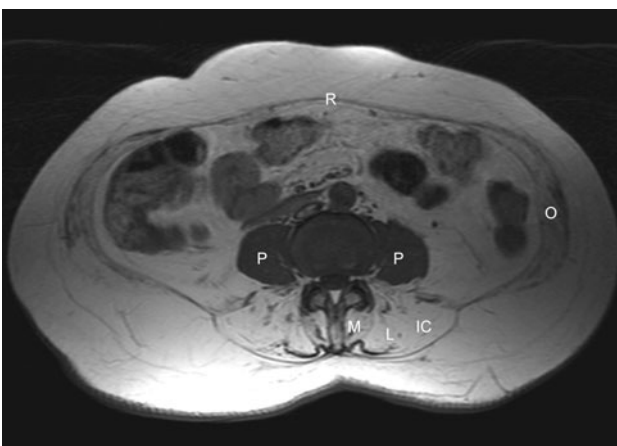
MRI scan T1 weighted, demonstrating fat replacement of lumbar erector spinae and abdominal muscles, completely sparing musculus psoas (pat. 6). *IC* iliocostal muscle, *L* longissimus muscle, *M* multifidus muscles, *P* psoas muscle, *O* abdominal oblique muscles, *R* rectus abdominus muscle
